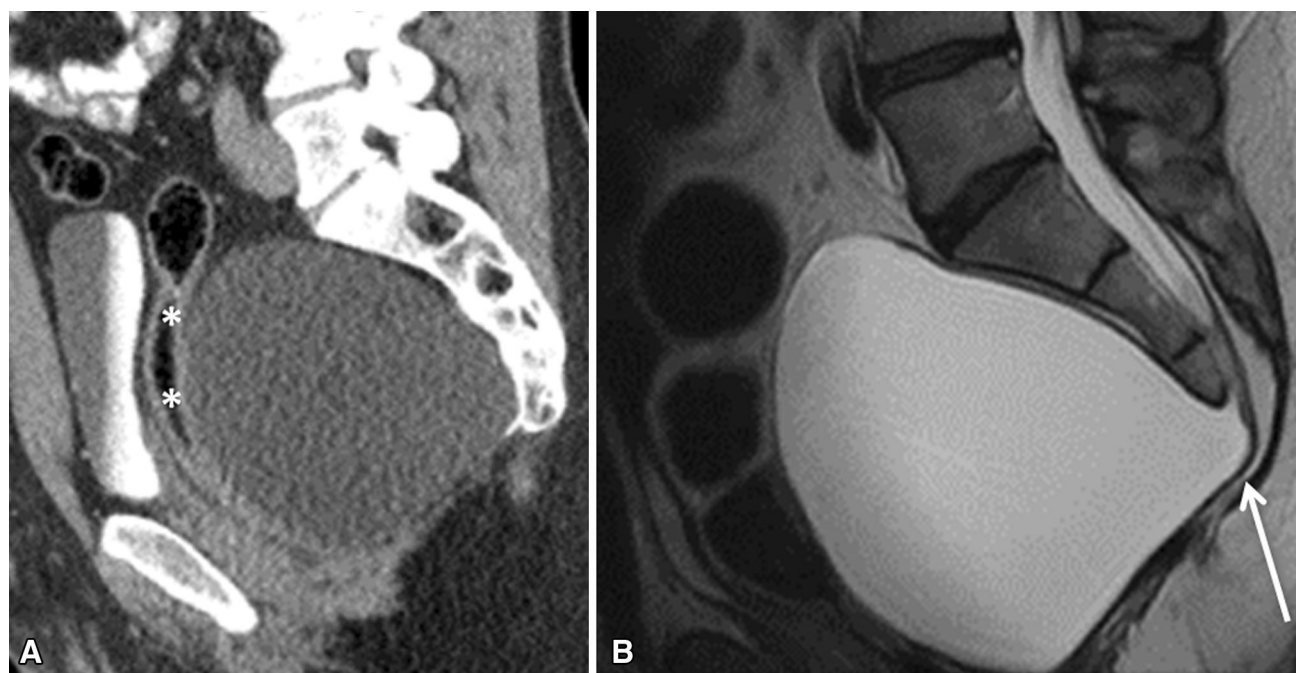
Anterior sacral meningocele. A CT demonstrates a large presacral cystic mass which contacts and displaces the rectum anteriorly (asterisks). B Sagittal T2-weighted MRI
